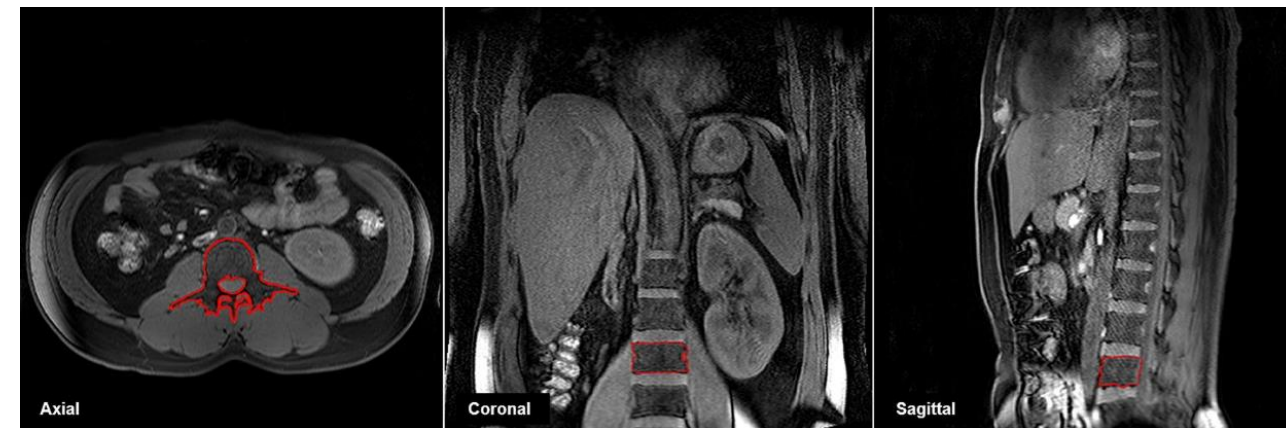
Computed tomography body composition analysis of the third lumbar vertebrae.
